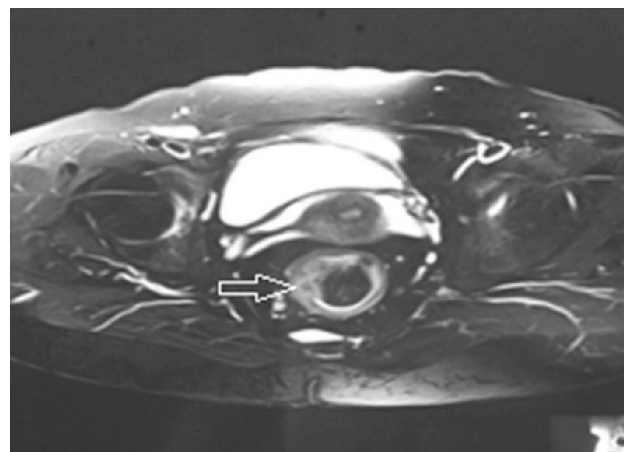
MRI appearance of the lesion (arrow)
